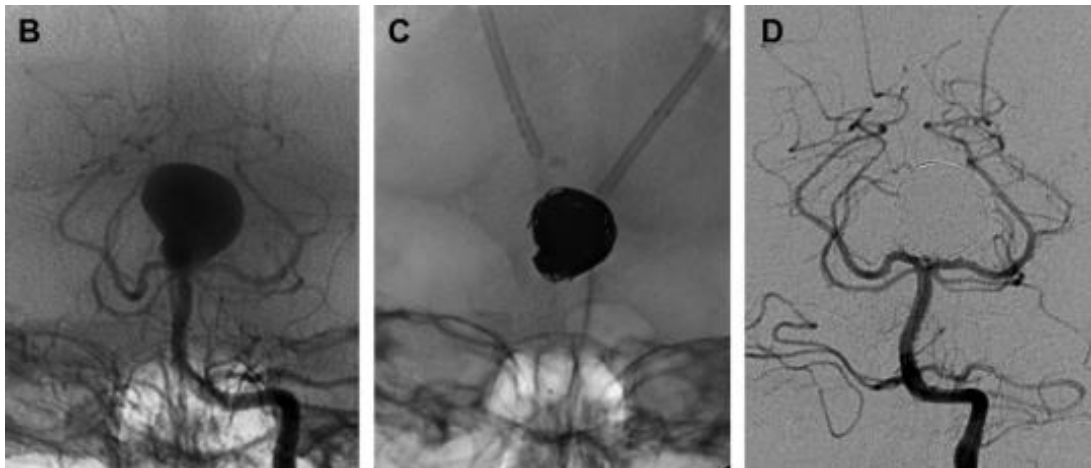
Head CT documenting diffuse SAH and IVH. The patient was transferred to the authors' institution for further management. (B) DSA, transfacial view, showing a large basilar tip aneurysm. (C) Nonsubtracted image of the pack of microcoils (bare platinum coils). (D) DSA, transfacial view after treatment. Mild irregularity is observed at the neck, but there is no residual opacification of the aneurysmal cavity.⁽³⁹⁾
